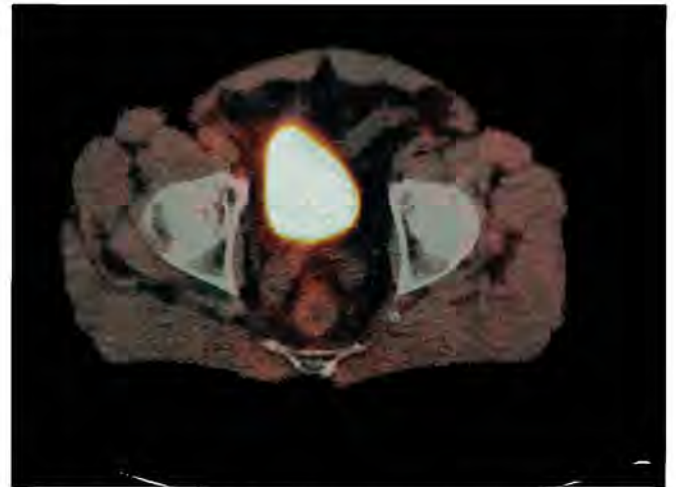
^{18}F -FLT PET/CT: absence of increased uptake in both primary tumor and lymph node metastasis. The patient was operated on and has been in clinical remission for 3 years now.
